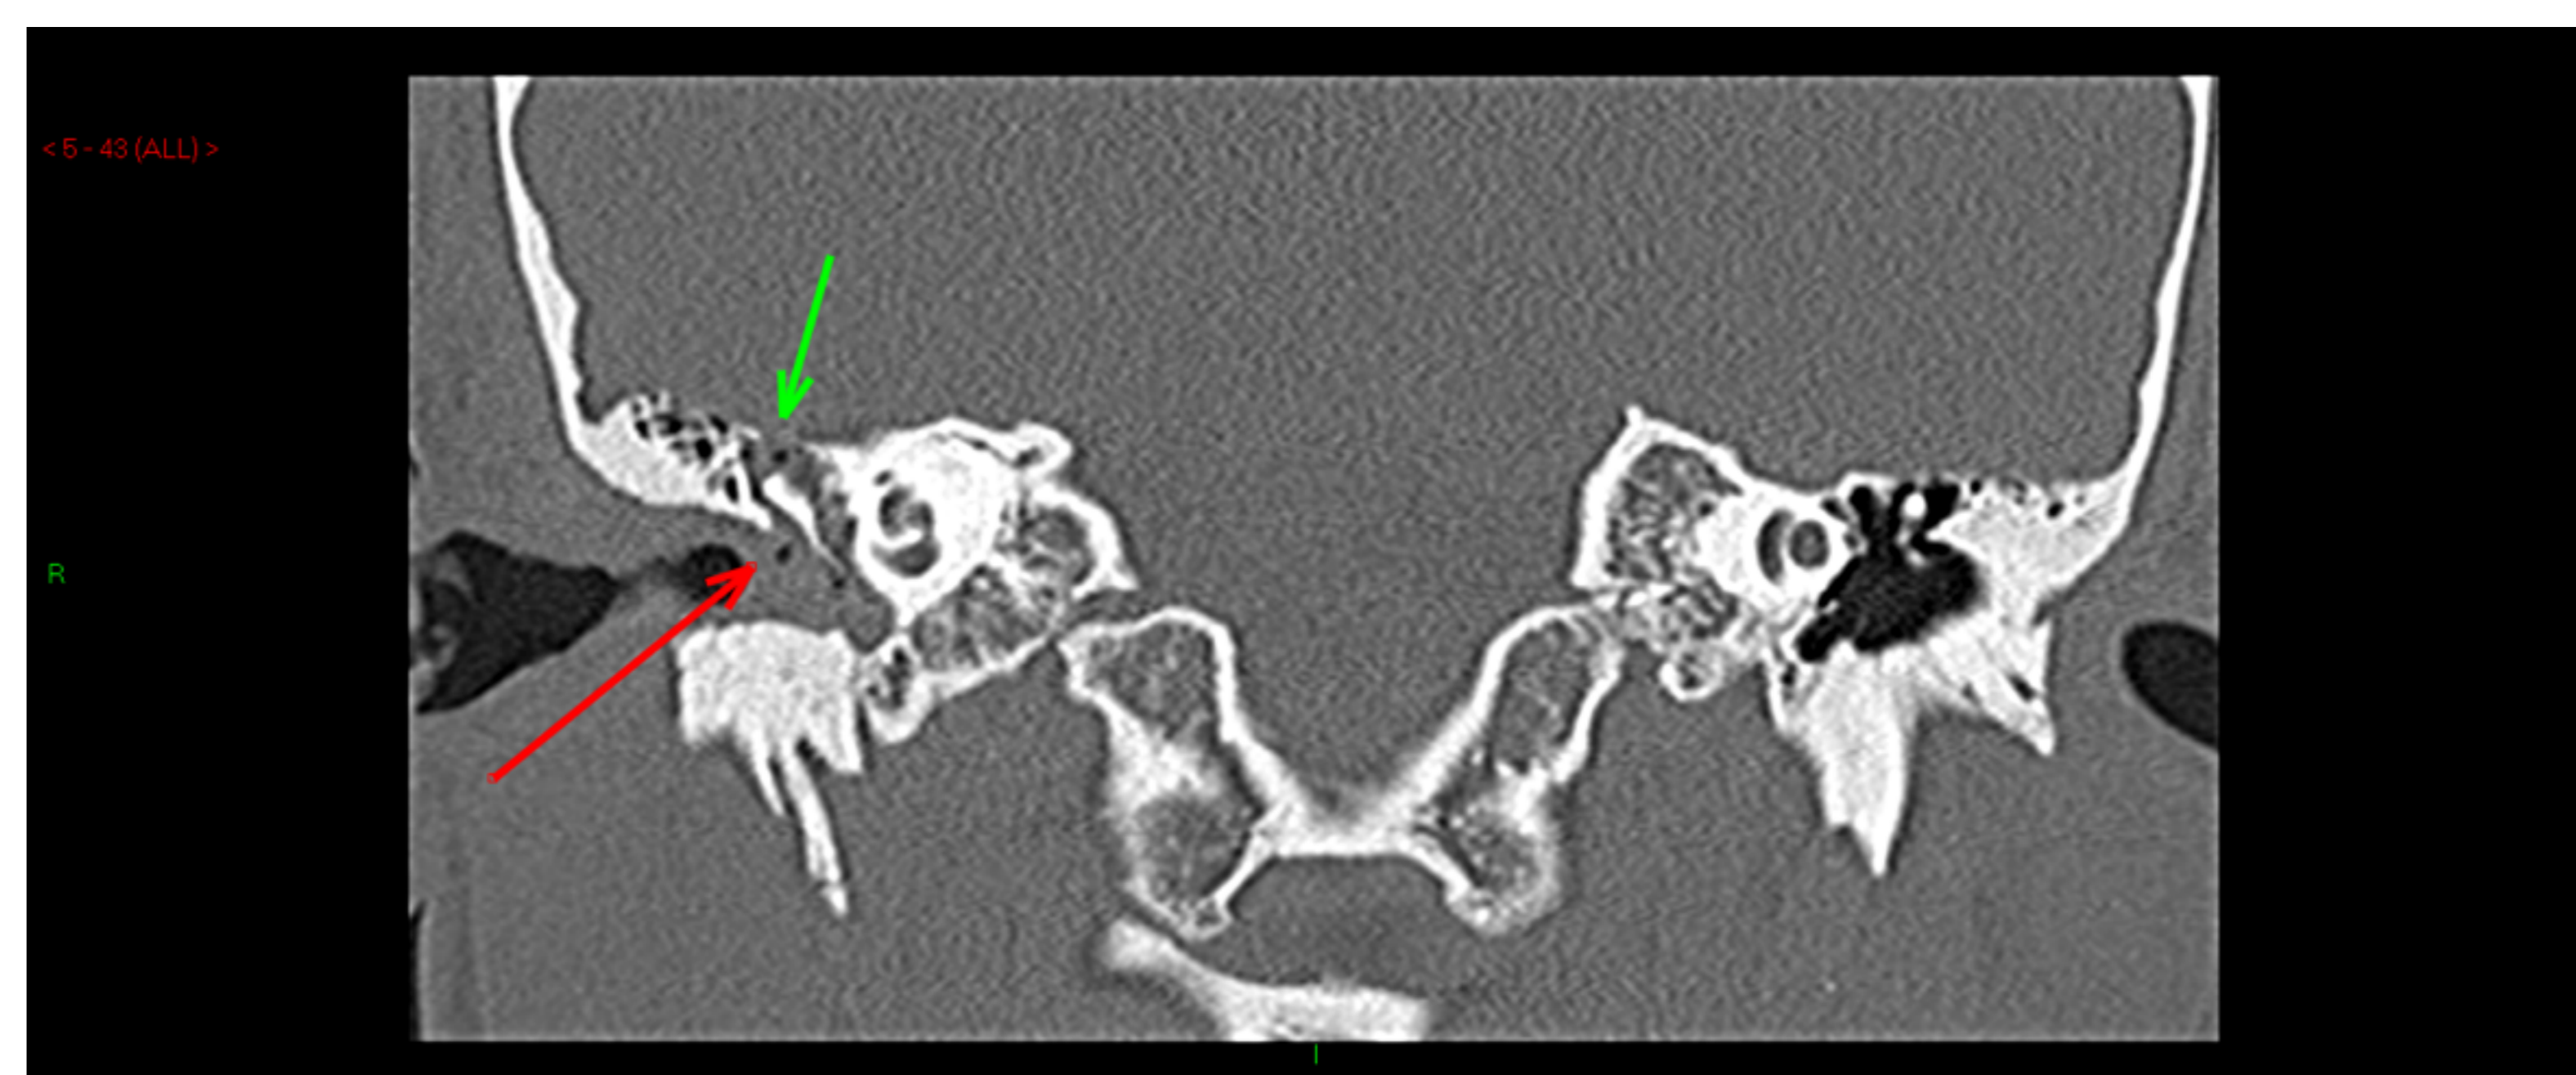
CT mastoid revealing tegumen breakdown and auditory canal thickening/inflammation
